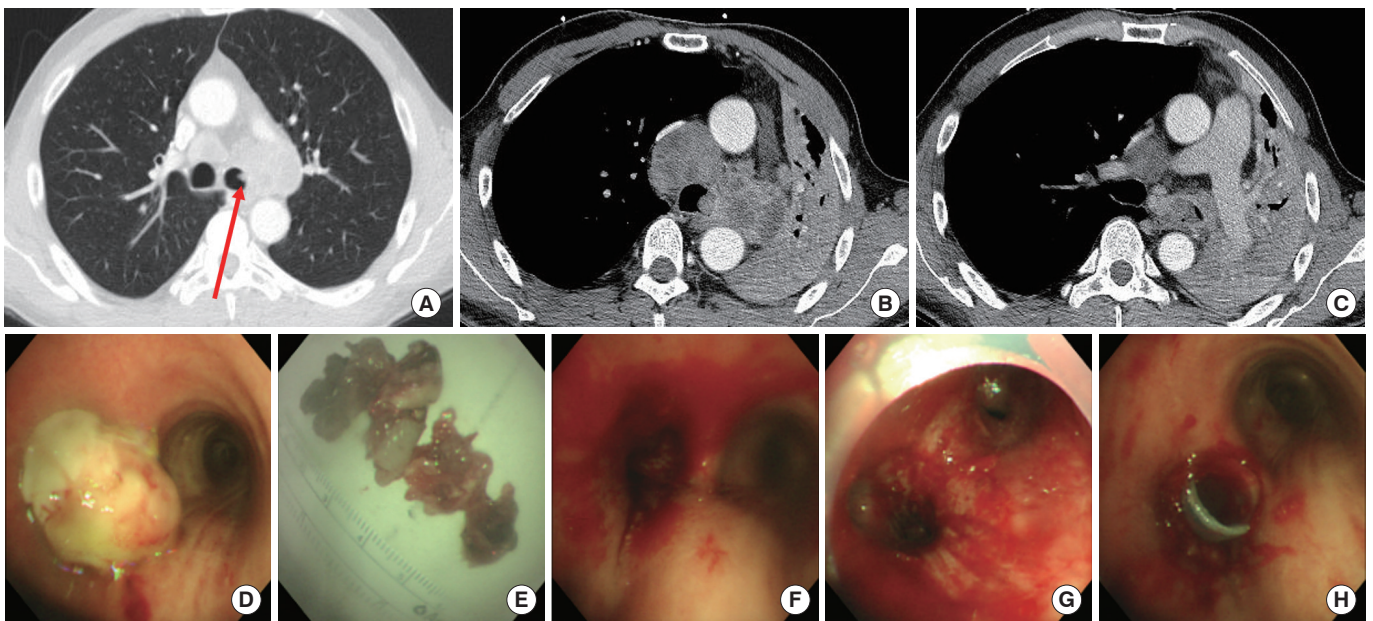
A representative case suitable for rigid bronchoscopy even in patients with complete atelectasis. A 59-year-old woman with renal cell carcinoma was hospitalized due to increased dyspnea with complete collapse of the left lung. (A, B) Chest computed tomography (CT) revealed that the left main bronchus was completely blocked from the midpoint (red arrow). (C) However, the chest CT showed pulmonary vessels with contrast enhancement (red circle), suggesting that blood circulation was maintained. In addition, secretions inside the airway and no necrosis of the lung parenchyma were found (red circle), suggesting that there were no problems in the peripheral airway and lung parenchyma. (D, E) Similar to the CT findings, rigid bronchoscopy showed complete obstruction from the midpoint of the left main bronchus. (F, G) The left main and left lower bronchi were secured by removing the tumor mass inside the airway.
